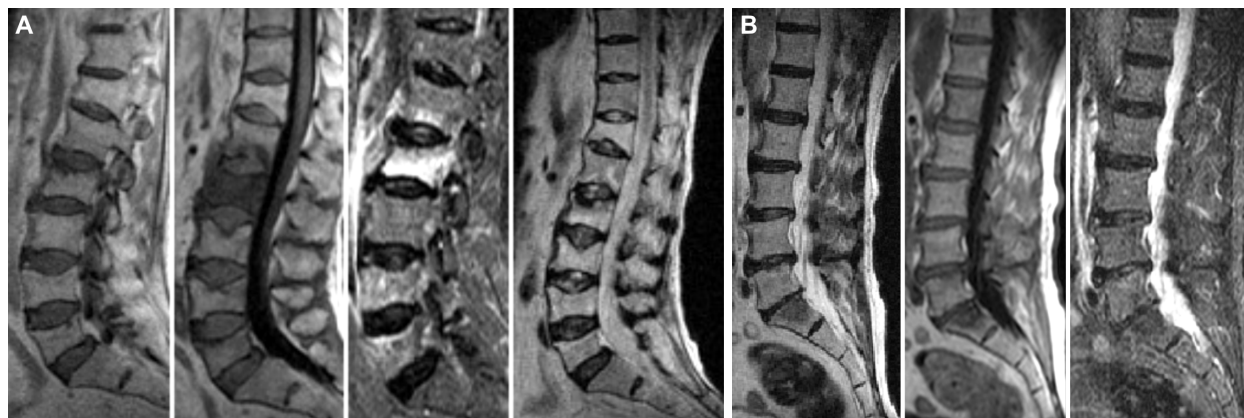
Lumbar spine MRI: (A) T2- and T1-weighted sequences, STIR sequence, and T1 post-contrast: BME on a patient with MH; (B) T2- and T1-weighted sequences, and STIR sequence: Bone metastases without BME. MRI: Magnetic resonance imaging; STIR: Short-tau inversion recovery; BME: Bone marrow edema; MH: Malignant hemopathy.
